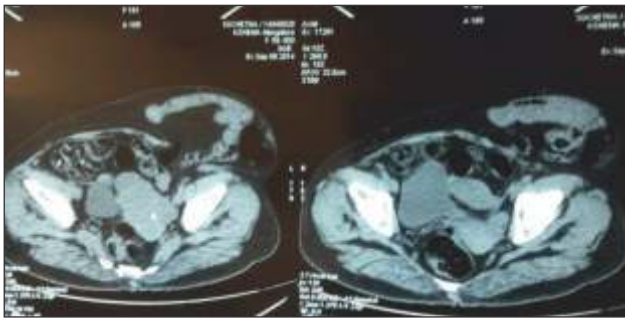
Pre op CT showing defect in the anterior abdominal wall with herniation of small bowel
